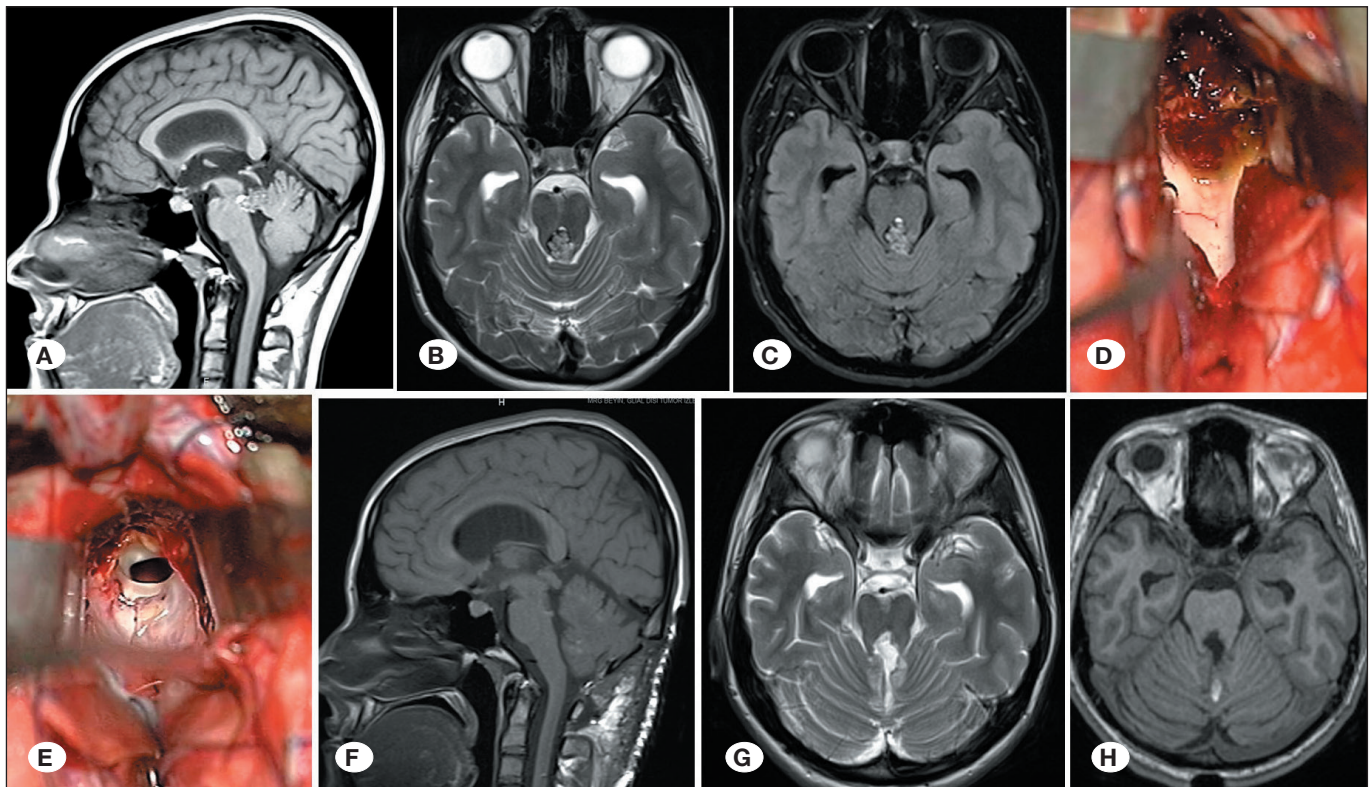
A 19-year-old female patient presented with a headache for several days. Magnetic resonance imaging (MRI) revealed obstructive hydrocephalus from a cavernoma within the aqueductus Sylvii (A: sagittal T1-weighted, B: axial T2-weighted, C: axial T1-weighted images). The patient was operated via midline suboccipital craniotomy. The vermis was partially split and the cavernoma obstructing the aqueduct was seen at the highest point of the 4th ventricle (D). Gross total resection of the cavernoma was performed and the aqueductus was opened (E). Post-operative MRI showed no residual lesion (F: sagittal T1-weighted, G: axial T2-weighted, H: axial T1-weighted images). The patient was discharged with normal neurological examination. She was still neurologically intact at her latest follow-up 36 months after surgery.
